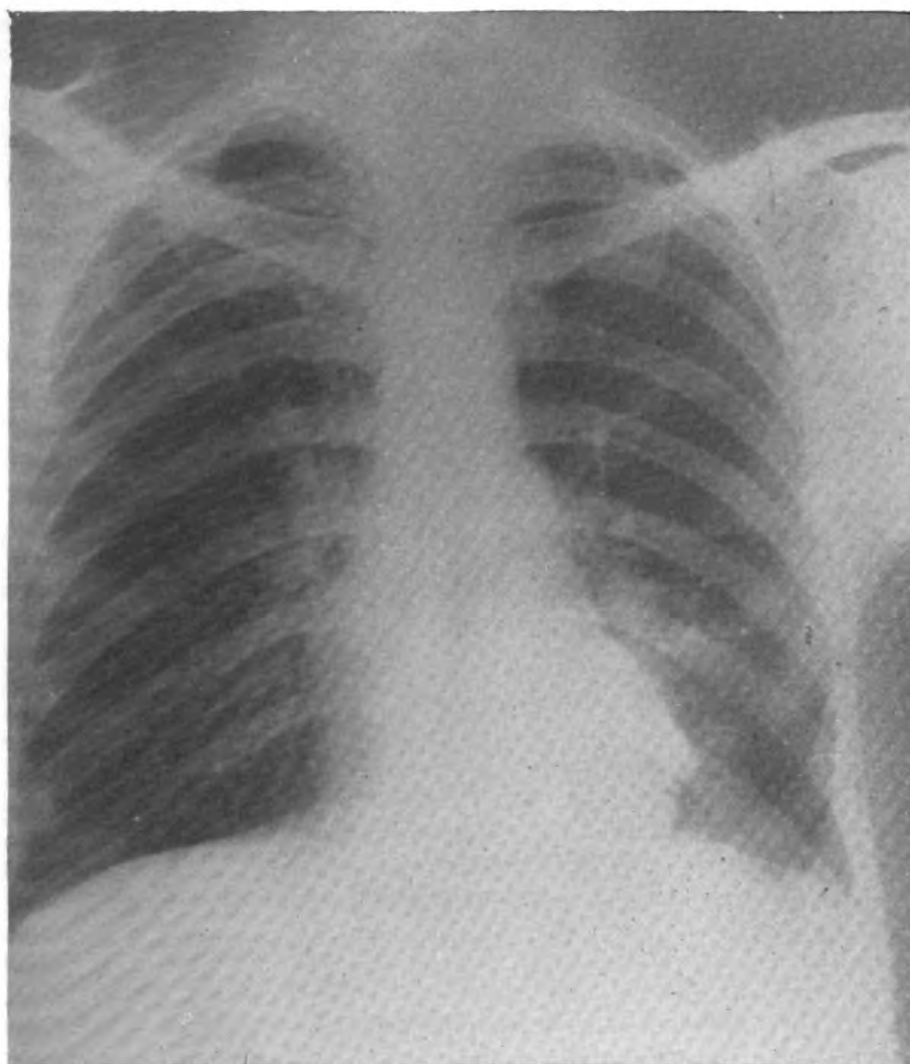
Final x-ray on 12 November 1945 showing almost complete resolution with residual fibrosis in the left lower and middle lung fields.
